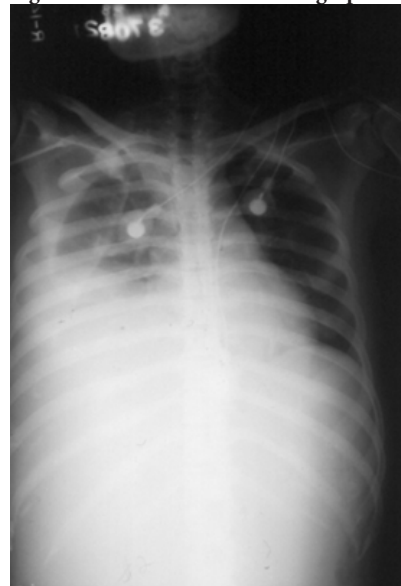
Portable chest radiograph obtained on admission demonstrating a large right-sided pleural effusion with associated elevation of the right hemidiaphragm and evidence of concurrent ascites. These findings are consistent with transdiaphragmatic extension of an amoebic liver abscess.
